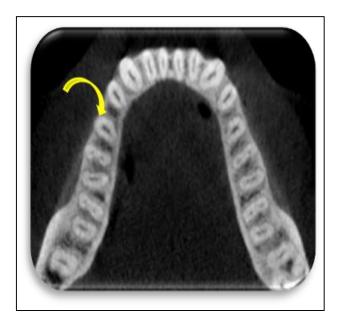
Axial view of CBCT at apical one third.
